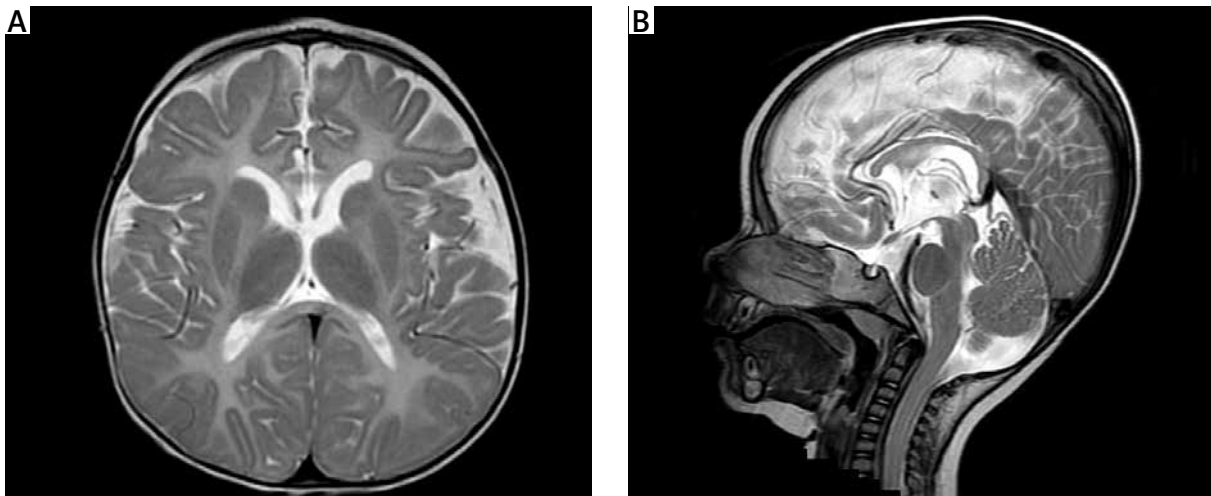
A) T2-weighted magnetic resonance imaging of the brain of a 1.5-year-old patient affected by Pelizaeus-Merzbacher disease. Transverse section – mild hyperintensity (as compared to cortex) of whole white matter is visible, also in posterior limb of internal capsules. B) Sagittal T2-weighted magnetic resonance imaging – see very thin corpus callosum due to the decreased white matter volume.
